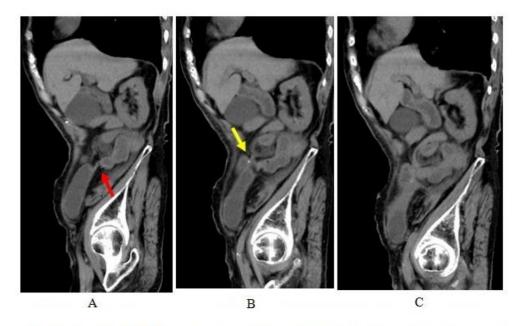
Sagittal CT images depict double beak signs (A red arrow, B yellow arrow) adjacent to cecum.
